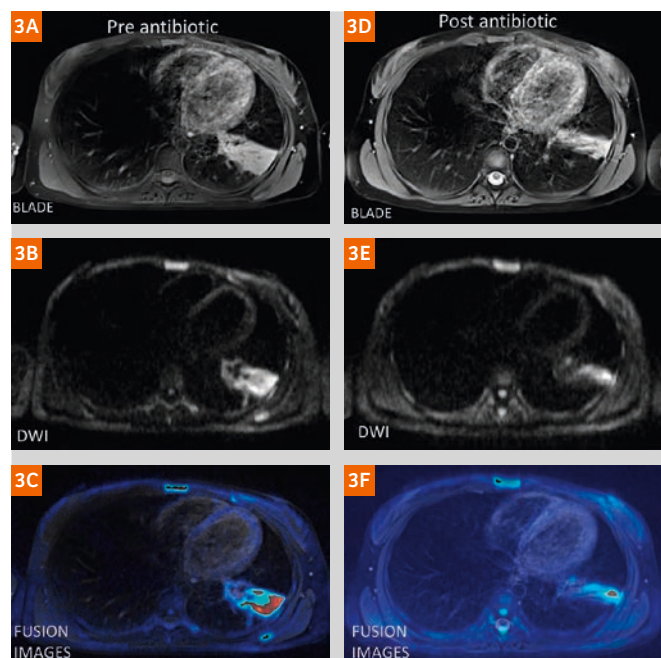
CF patient with pulmonary exacerbation, MRI pre (left column) and post (right column) intravenous antibiotic treatment. (3A, D) axial BLADE PD-weighted end-expiratory navigator triggered; (3B, E) axial DWI b=800 and (3C, F) FUSION image (DWI superimposed to BLADE). Note that between first and second MRI scan there is not only a reduction of the left lower lobe consolidation but also a consensual reduction of DWI signal (arrows in 3C, F).
